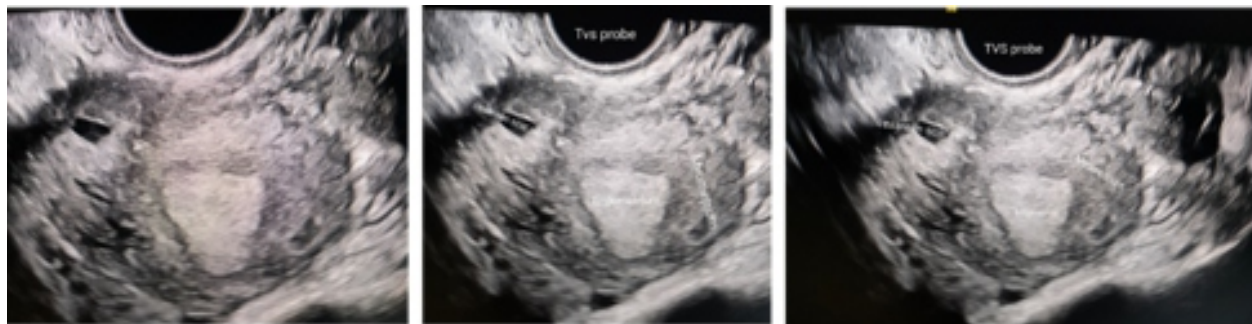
Transvaginal Ultrasound Image of Cesarean Scar in a Patient with a Previous Lower Segment Cesarean Section Performed 8 Months Ago, Showing Thinning of the Scar (Niche).
